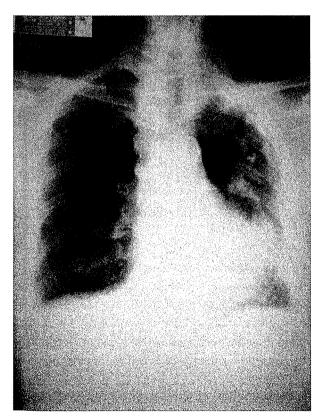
Chest radiography on admission shows enlargement of the cardiac silhouette.
